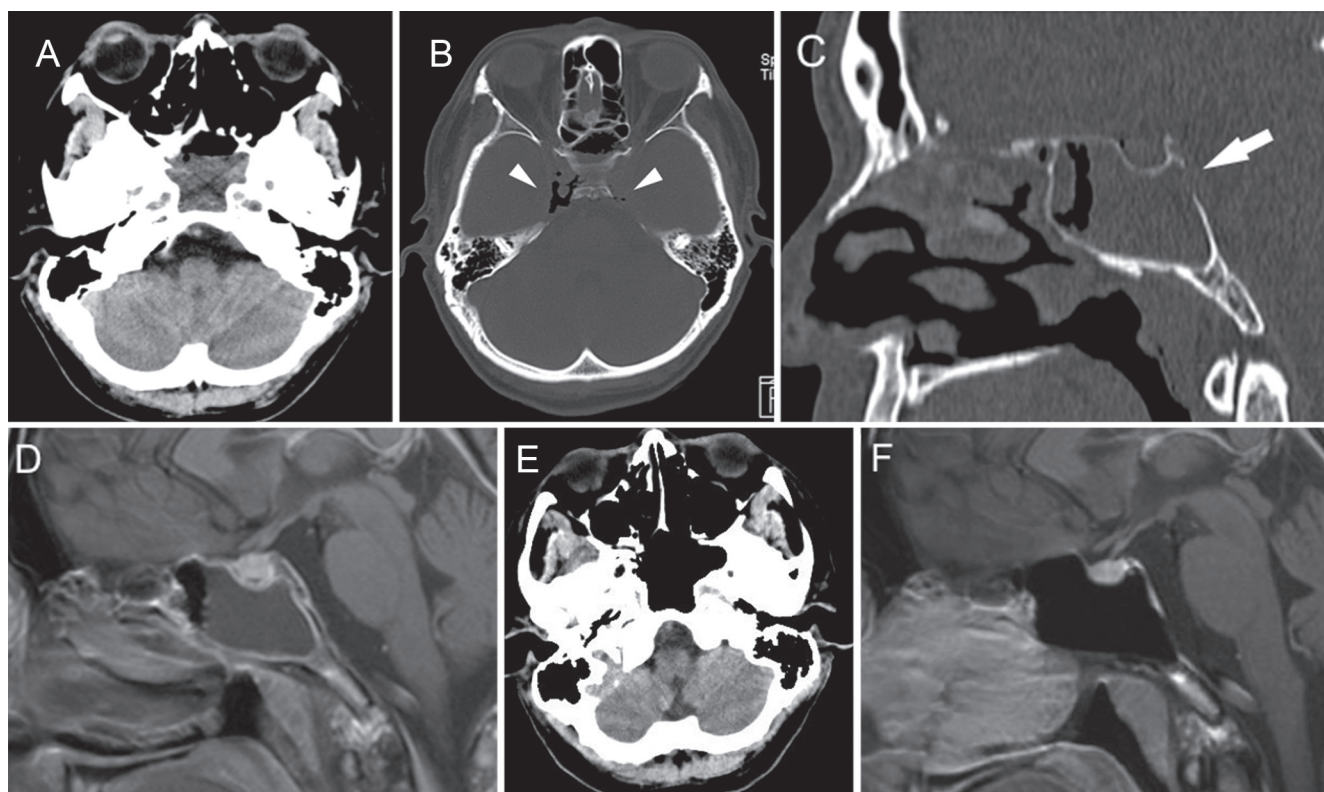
Computed tomographic (CT) scans and magnetic resonance (MR) images of the patient. A: An axial, non-enhanced CT image on admission demonstrated opacified sphenoid sinus. B: Bone window of axial CT image demonstrated free air (arrowheads) in the bilateral cavernous sinus on admission. C: A sagittal, non-enhanced CT image revealed a defect (arrow) in the posterior wall of sphenoid sinus. D: A sagittal T₁-weighted gadolinium enhanced MR image on admission demonstrated opacified sphenoid sinus and enhanced peripheral mucous membrane. The dura covering the clivus was enhanced. E: No accumulation of fluid was found with non-enhanced axial CT image during the follow-up. F: A follow-up sagittal T₁-weighted gadolinium enhanced MR image revealed that an enhanced peripheral mucous membrane of the sphenoid sinus diminished. The enhancement of the dura covering the clivus was markedly decreased.
